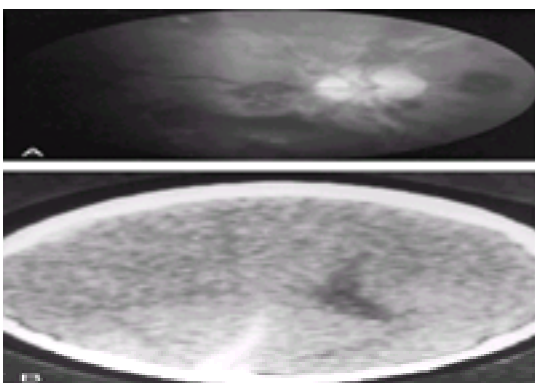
Manifestations of the whiplash shaking injury. A. Retinal hemorrhages as seen on fundoscopic examination. B. Computed tomogram showing intrahemispheric subdural bleeding and right cortical brain swelling.
